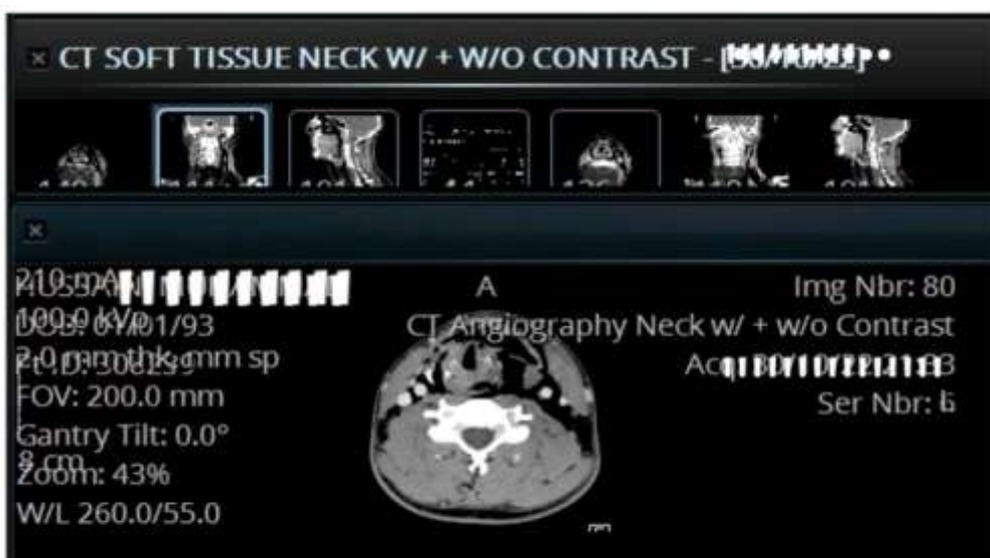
CT scan of neck showing air leak into soft tissues of neck.
